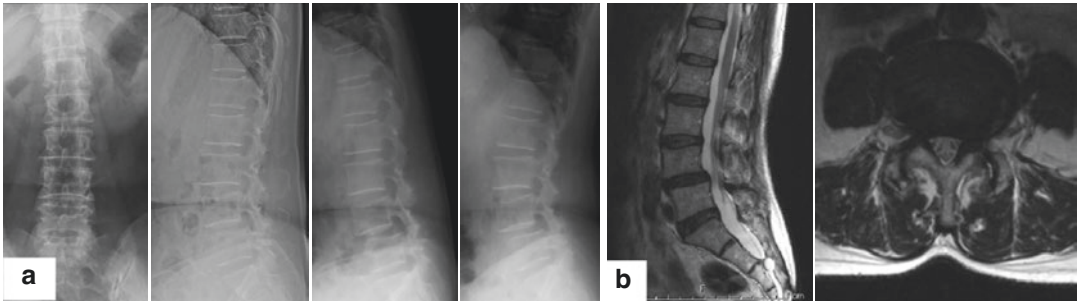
(a) Preoperative radiographs of a patient showing listhesis with dynamic instability at L4–5 level (b) MRI image of the same patient showing stenosis at L4–5 level
